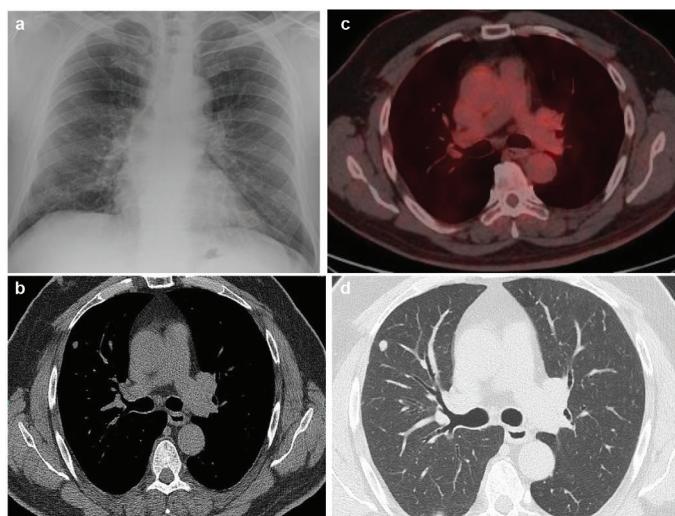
(a) Posteroanterior chest radiograph showing bilateral reticulonodular opacities. (b) Axial chest CT demonstrates a 12 mm well circumscribed nodule in the right lower lobe. (c) Fused ¹⁸F FDG PET/CT shows mild hypermetabolic uptake in the same lesion (SUV_{max} 4.8). (d) High-resolution CT confirms a solid subpleural nodule with sharp margins.
